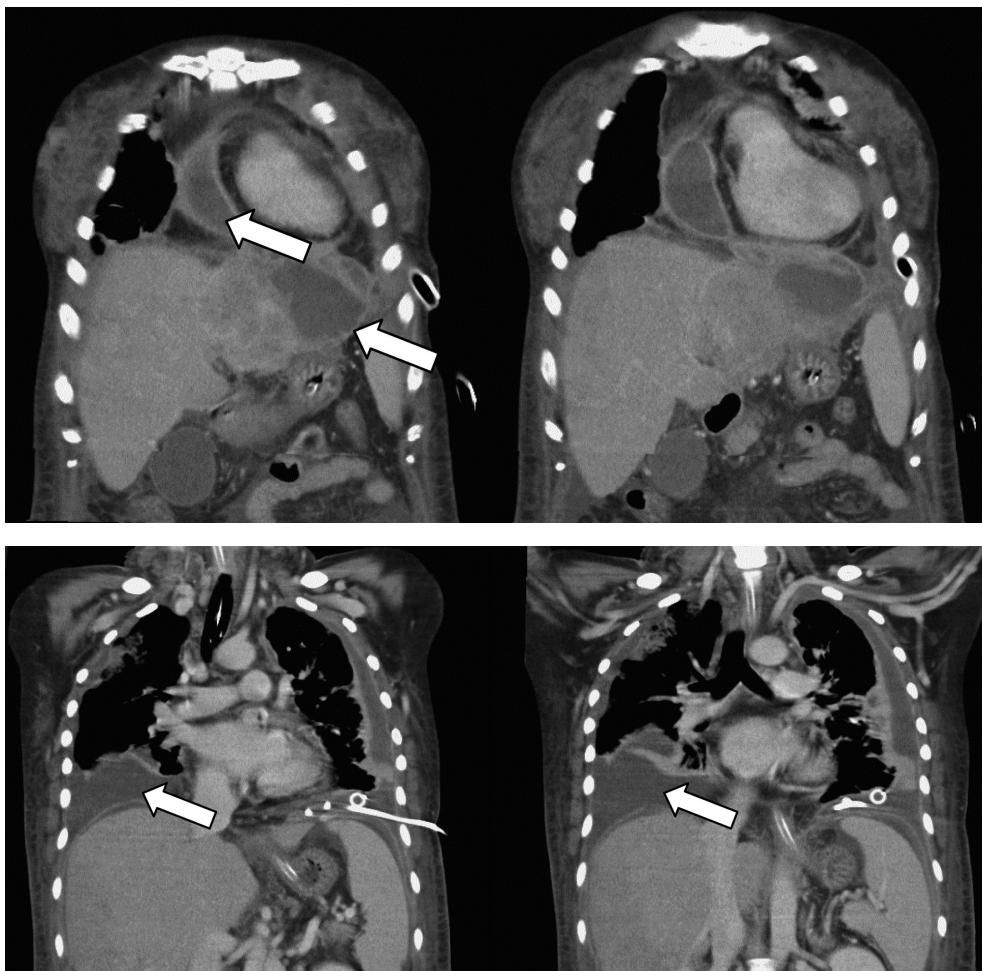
Serial saggital non-contrast CT scan images showing a low attenuating lesion in the liver, pericardium, and pleural space (arrow), which was suggestive of liver abscess, pericardial effusion, and empyema
